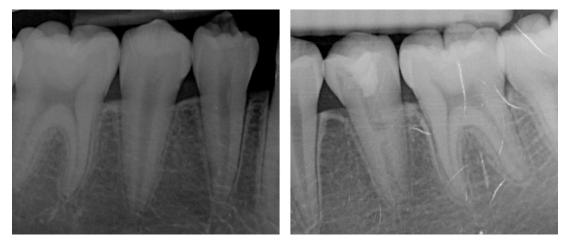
Periapical films of teeth 35 and 45 at the 18-month follow-up visit. The radiolucent apical lesion of tooth 35 had healed, and there were increases in root length and root wall thickness observed in both teeth 35 and 45.
